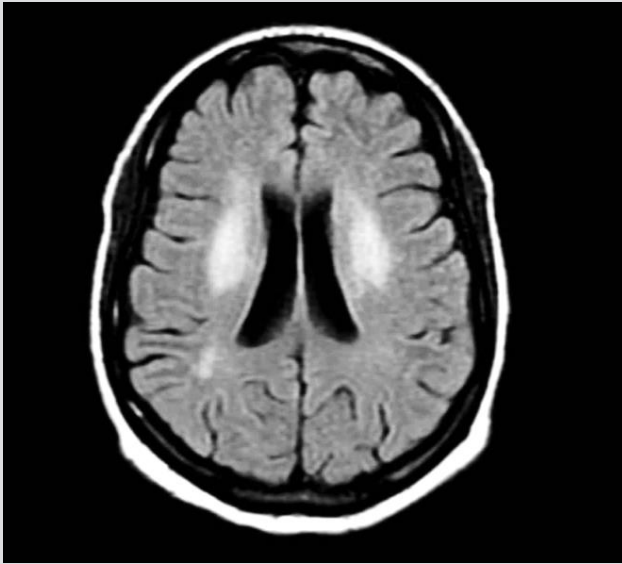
Fluid-attenuated inversion recovery (FLAIR)-weighted brain magnetic resonance imaging showing bilateral hypersignal of the corona radiata and left subcortical right parietal lesion in a patient with active neuropsychiatric systemic lupus erythematosus.
